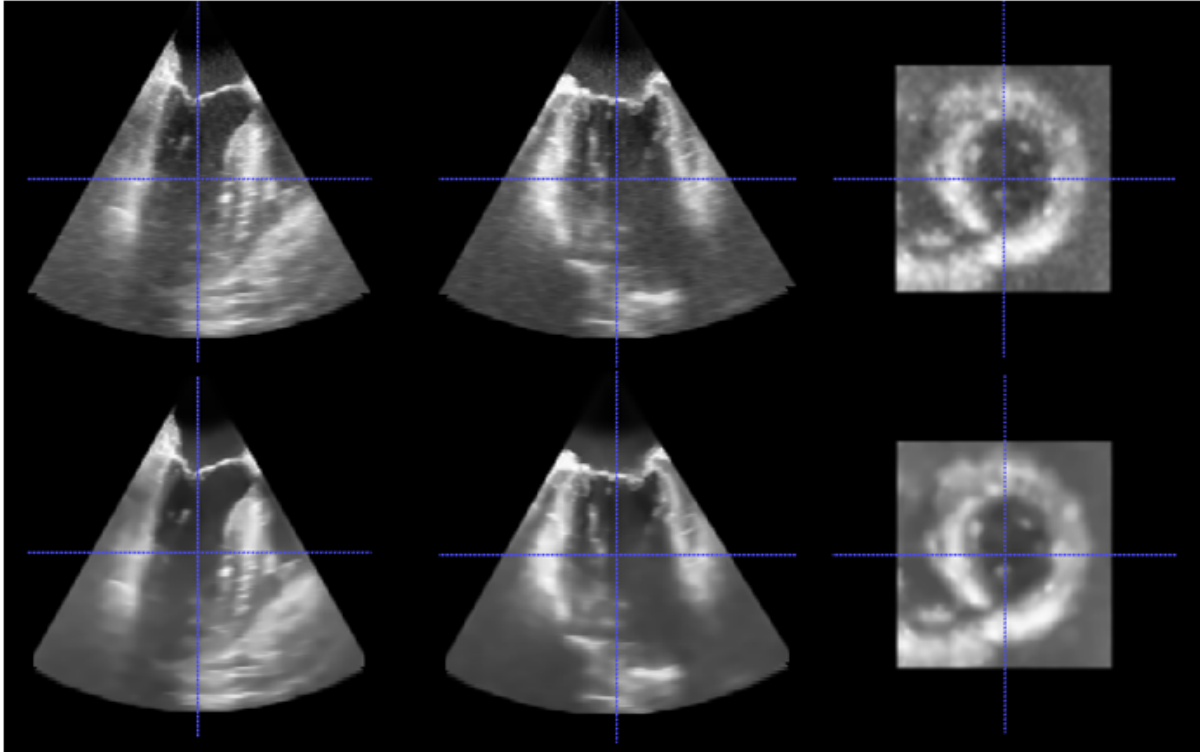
An example of ultrasound images smoothed by nonlocal means based filtering. First row: original TEE image. Second row: nonlocal means smooth image. Speckle is greatly reduced, while anatomical features are mainly retained in the smoothed images.
